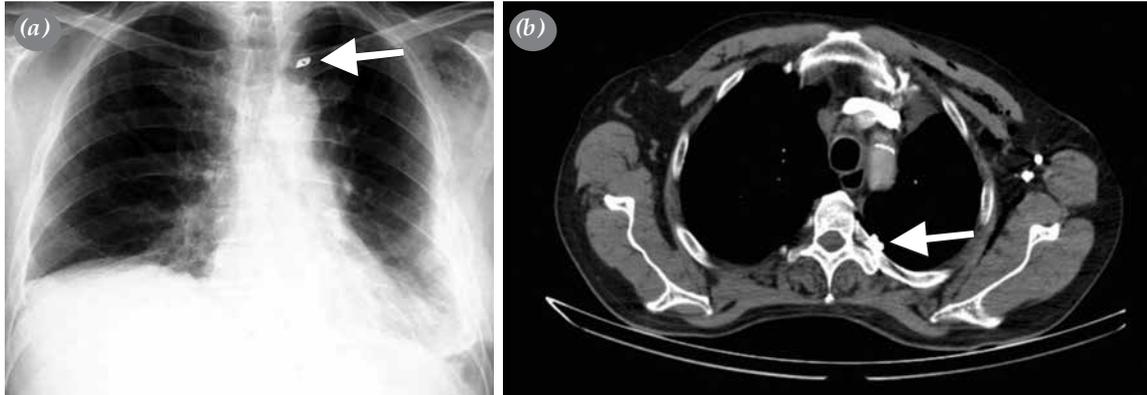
(a) Postoperative chest X-ray showing a metallic object located in left hemithorax (arrow). (b) Computed tomography verifying metallic object in posterior left hemithorax (arrow).
